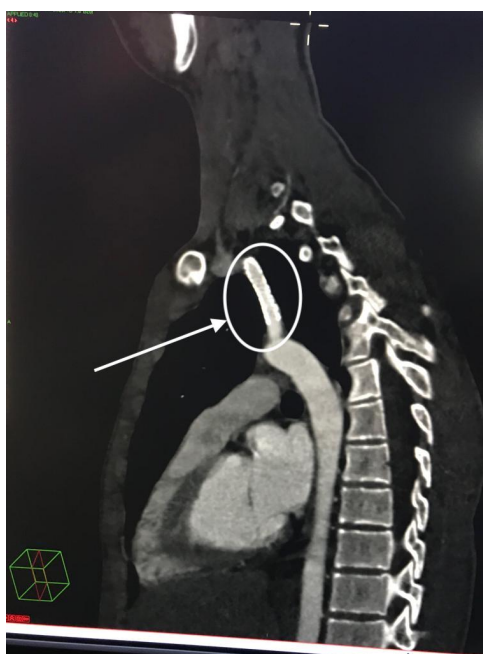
Sagittal view computed tomography of chest showing the stent-graft (arrow).
